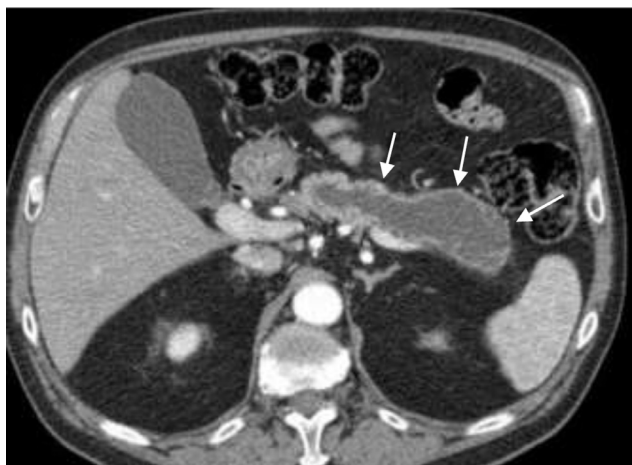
Axial contrast-enhanced CT from initial presentation in October 2011 shows a low attenuation mass in the pancreatic body and tail (arrows).
